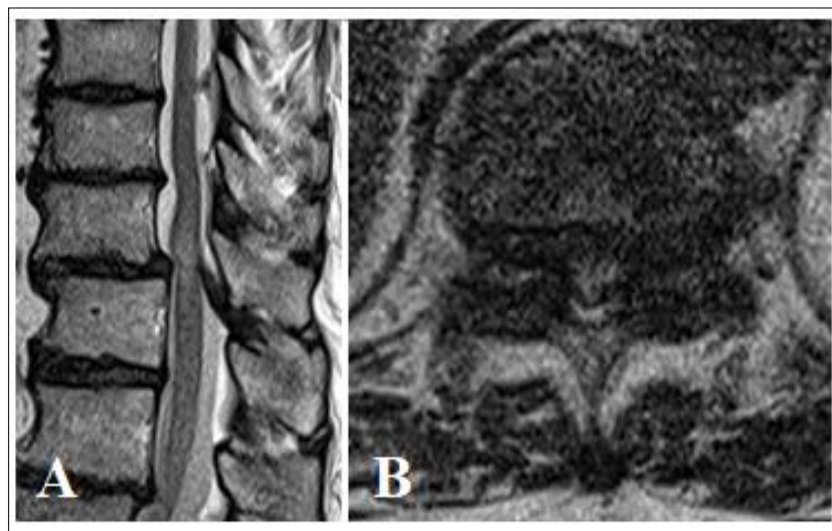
Spinal cord compression between T11 and T12 and high-intensity changes in spinal cord observed on T2-weighted magnetic resonance images. A: sagittal B: axial.
